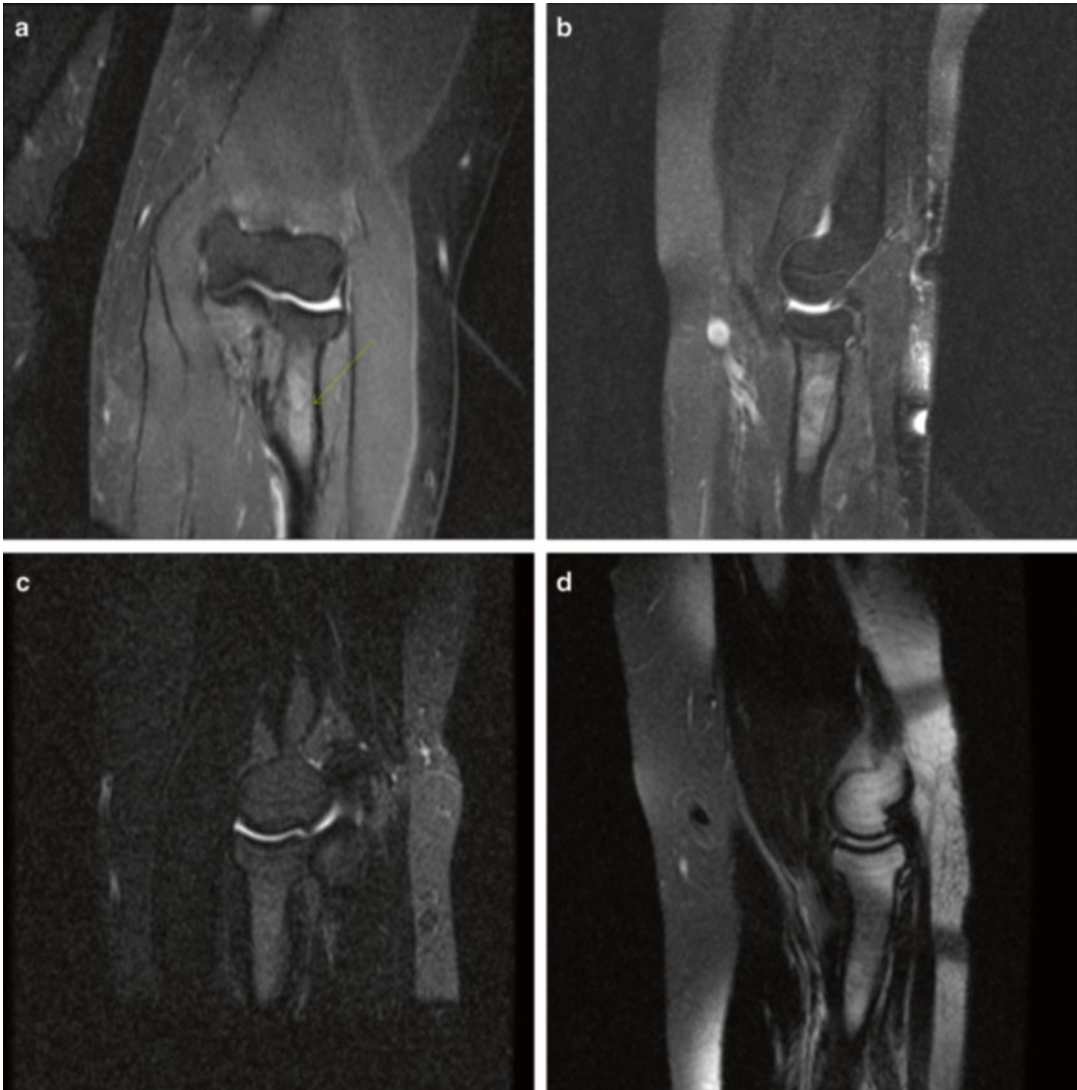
A 40-year-old nurse who presented with a 3-month history of elbow pain with weight bearing in terminal extension. Plain radiographs were normal. (a) Coronal STIR image of the left elbow demonstrating proximal radius stress fracture. (b) Sagittal T2-weighted
